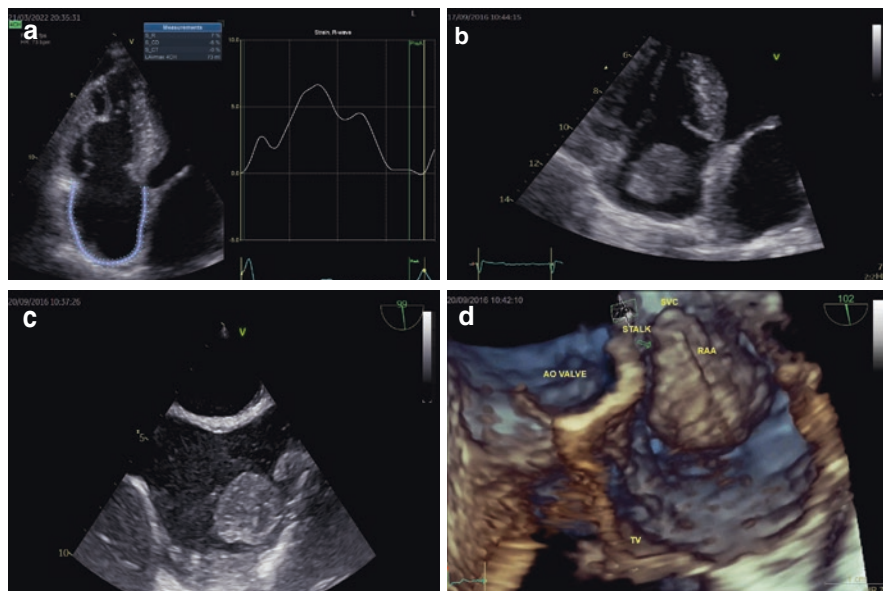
AL cardiac amyloidosis patient in sinus rhythm. Transthoracic echocardiogram right atrial longitudinal strain (LS) analysis (a) showing reduced global LS (7%) because of markedly infiltration of right atrial wall with amyloid, leading to electromechanical dissociation. In (b) from an apical RV focused view with zoom we can see a large thrombus inside the right atrium (RA). In (c) from a bicavum transesophageal view the large thrombus is attached to the right atrial (RA) appendage, seen with more details in (d) with three-dimensional rendered images. TV Tricuspid valve, AO Aortic, SVC Superior-Vena cava, RA right atrium
